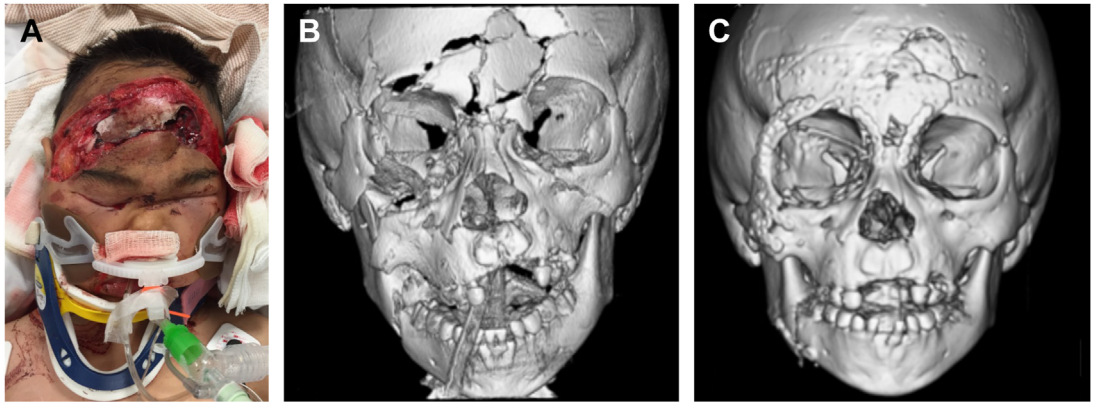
(A) Traditional panfacial presentation. A 5-year-old boy involved in an all terrain vehicle (ATV) rollover presenting with panfacial fractures. Secondary survey is notable for a large transverse full-thickness forehead laceration with open, comminuted fractures of the frontal bone. (B) Preoperative CT imaging. Underlying fractures include comminuted, displaced frontal bone fractures, severely displaced right LeFort 1/2/3 fractures, mild-to-moderately displaced left LeFort 2 fracture, and severely displaced right mandibular body fracture with malocclusion. (C) Immediate postoperative fracture fixation. Through a top-down, outside-in approach, he underwent ORIF of his bifrontal bone fractures using a resorbable plating system followed by titanium fixation of the right zygoma and the bilateral NOE segments. Following established of midface width and projection, he underwent upper titanium fixation of his right maxilla along the zygomaticomaxillary "buttress" to restore midfacial height through an upper sulcus intraoral approach. Finally, he underwent titanium fixation of the right mandibular body using monocortical fixation along the inferior border through an extraoral approach to control for lingual splay. The remaining nondisplaced and mildly displaced fractures were allowed to heal and remodel.
